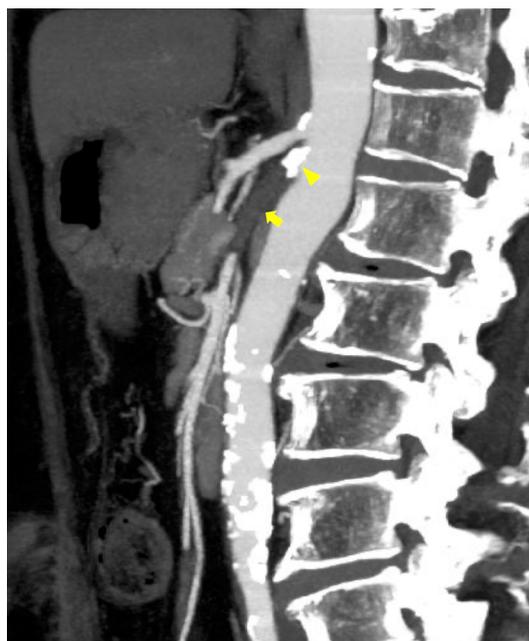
Sagittal images of abdominal contrast-enhanced CT showed calcification (yellow arrowhead) and total occlusion (yellow arrow) of the proximal superior mesenteric artery.
